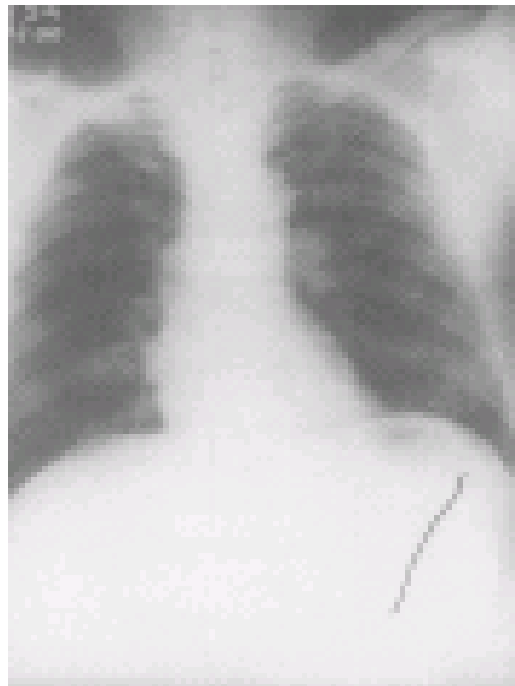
Chest radiograph PA and lateral views showing soft tissue density mass abutting the chest wall in the anterior aspect of the right lower lobe.
